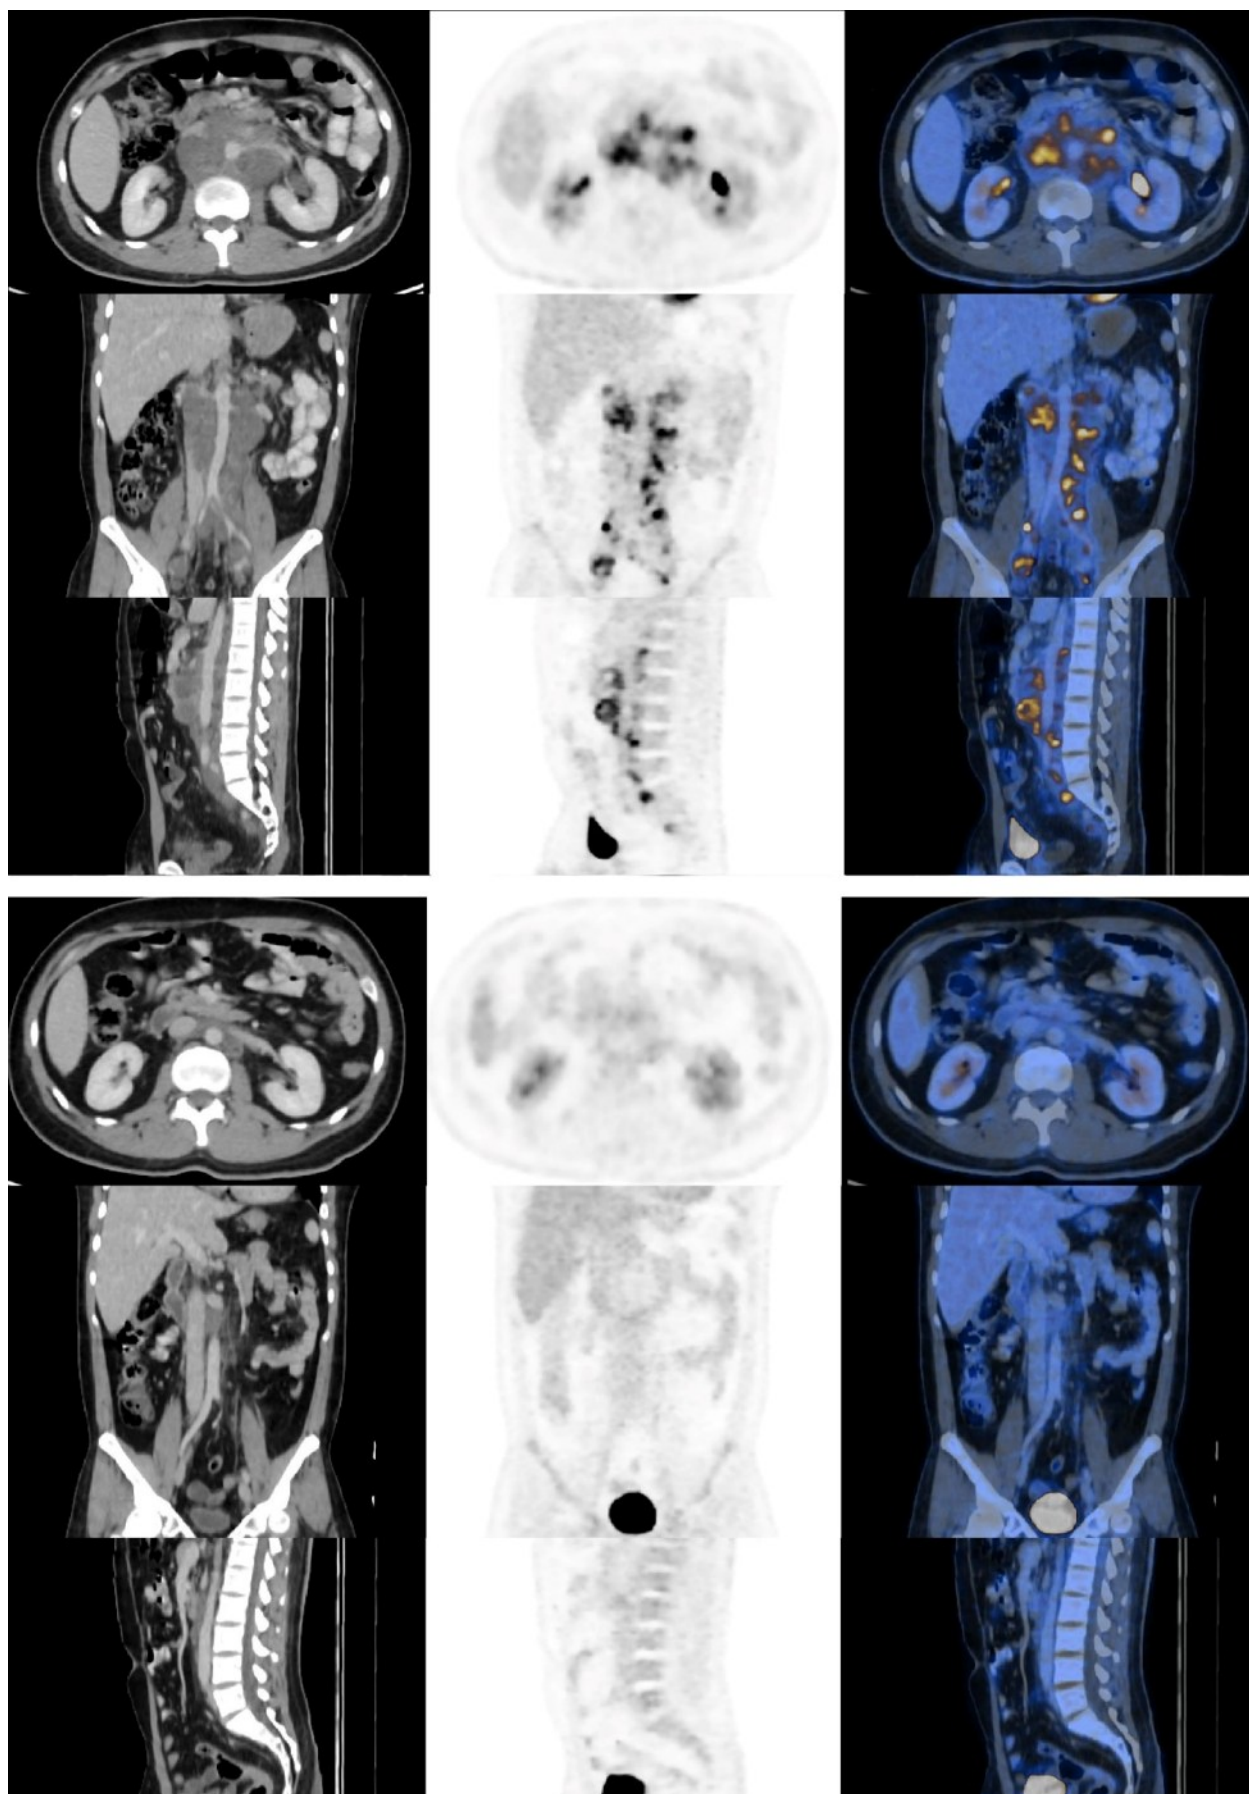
Axial, coronal and sagittal view showing the (A) CT, (B) PET, and (C) fused PET/CT images of the patient's second whole-body PET/CT scan showing resolution of the abdominal lymphadenopathies. Initial PET/CT scan (1st row) and follow-up PET/CT scan (2nd row) region.
